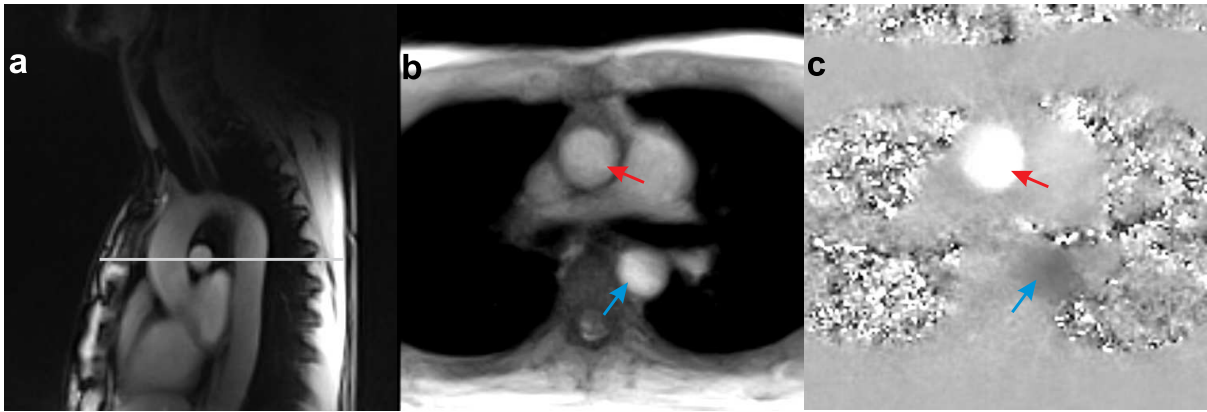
Real-time PC MRI of through-plane flow in the ascending aorta. (a) sagittal view of the human aortic arch with transverse slice orientation, (b) magnitude image and (c) phase-contrast map of the transversal view. Arrows indicate the flow in ascending aorta (red) and descending aorta (blue).
